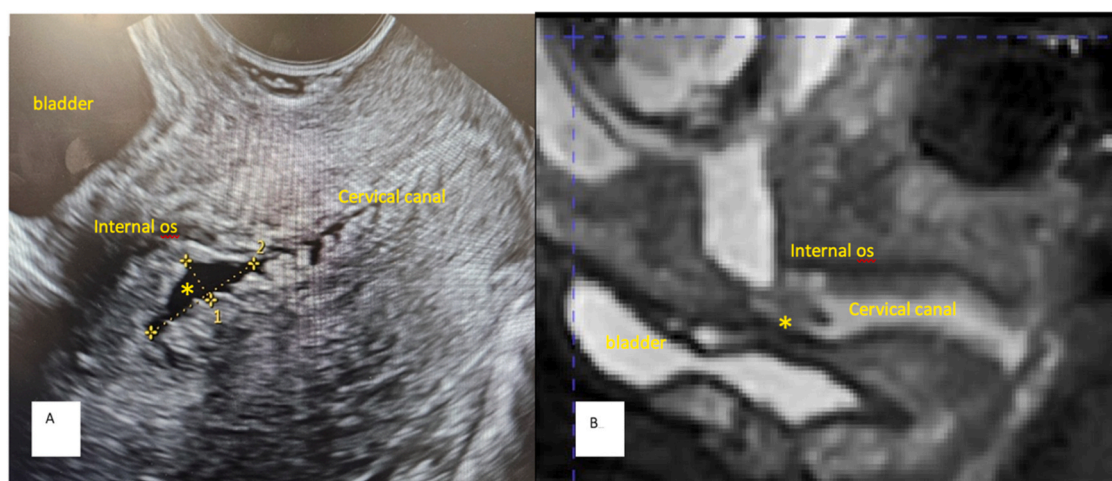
TVUS (A) and T2 3D MRI reconstruction (B) demonstrating a cervical niche (*) at 23 weeks in a pregnancy following a full dilatation section [CRAFT-IMG study REC 19/L0/1270].
